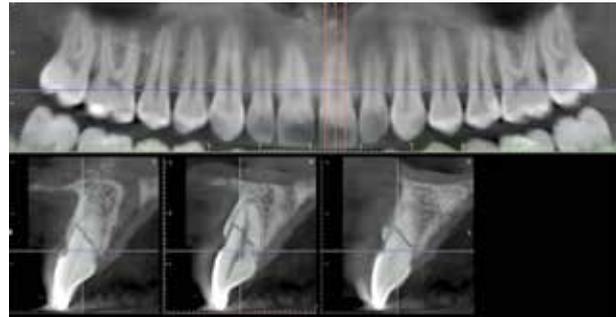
Preoperative CBCT scan image of tooth 21. The buccal plate was recognized.
